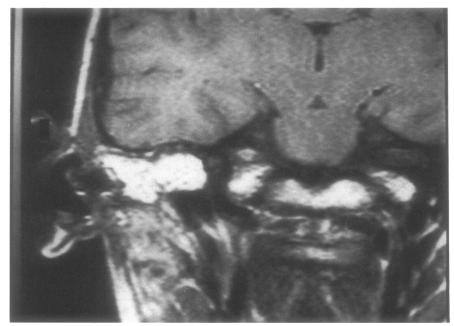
Supralabyrinthine cholesteatoma. MRI, coronal section, 3 years postoperatively shows that the cavity is completely obliterated with abdominal fat. No sign of residual disease is present.
